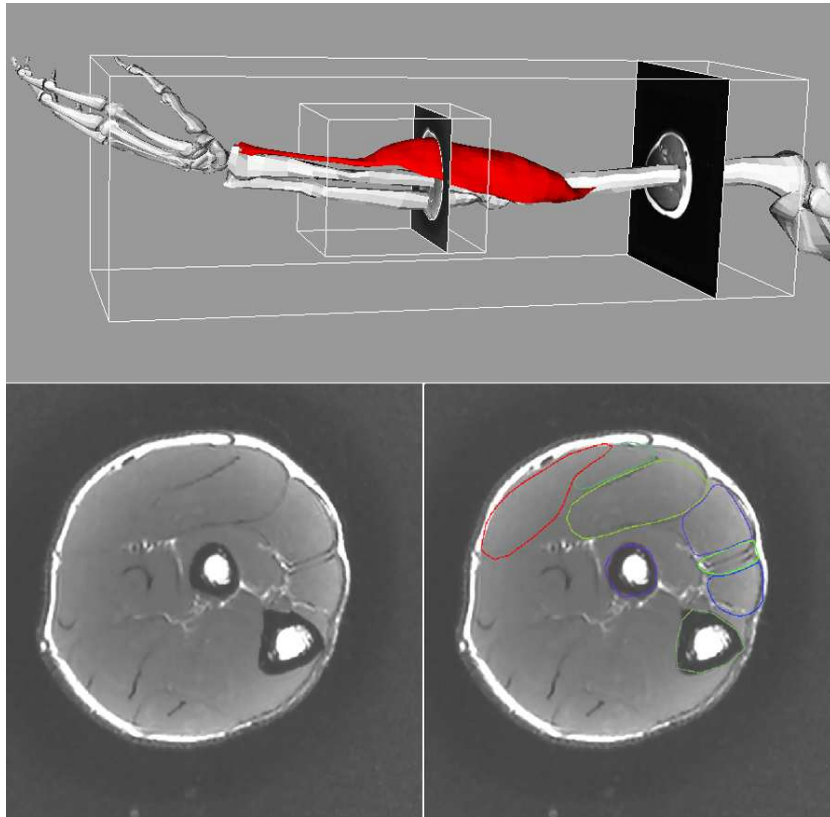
Left: High/ low resolution MRI volumes and reconstructed models (bones and Brachioradialis muscle) of the arm. Bottom: High resolution sample slice with and without superimposed models. Note that the Brachioradialis is shown in red while other muscles in the forearm are shown as contours of different colours.
